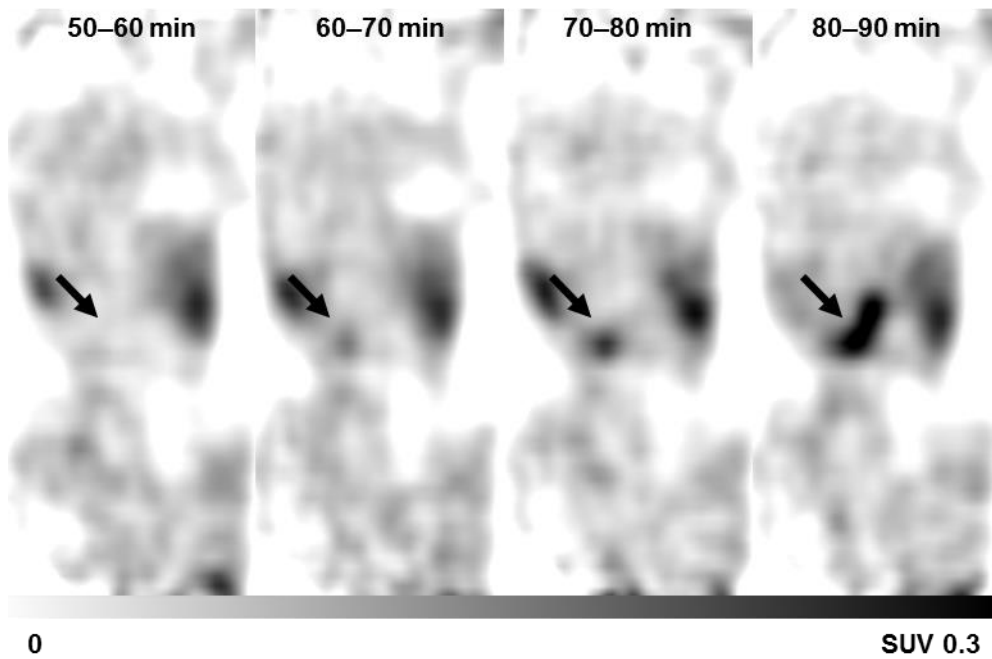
[^{18}F]FLT uptake in the abdominal aorta was visualised late in the 90-min scan. Representative coronal-view PET images of dynamic AAA uptake of [^{18}F]FLT from 50 to 90 min post-radiotracer injection. Colour scale bar indicates SUV thresholding to aid visualisation. Arrows indicate the AAA.
